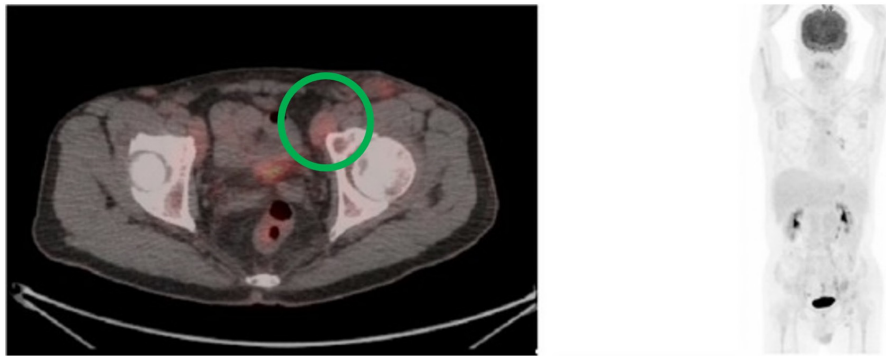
Whole-body FDG PET/CT scan. Initial PET/CT scan showed multiple low-grade FDG-avid nodules over several lymphatic sites on both sides of the diaphragm, with the most intense FDG avidity being over the left internal iliac chain. The left panel shows an axial view at the hip level of the PET/CT. The red coloration indicates high radiotracer uptake, such as active metabolic processes (malignancy or inflammation). The right panel shows a coronal view of the MIP PET image. The green circle indicates the most intense FDG avidity (with a maximal standardized uptake value of ~6.6 at the left internal iliac chain). PET-CT, positron emission tomography-computed tomography; FDG, 18-fluorodeoxyglucose; ROI, region of interest; MIP, maximum intensity projection.
